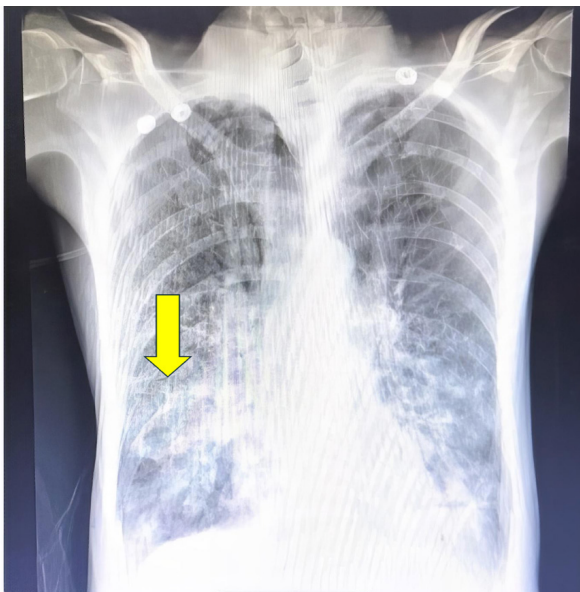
Chest X-ray showing hyperinflated chest with bilateral bronchiectasis
